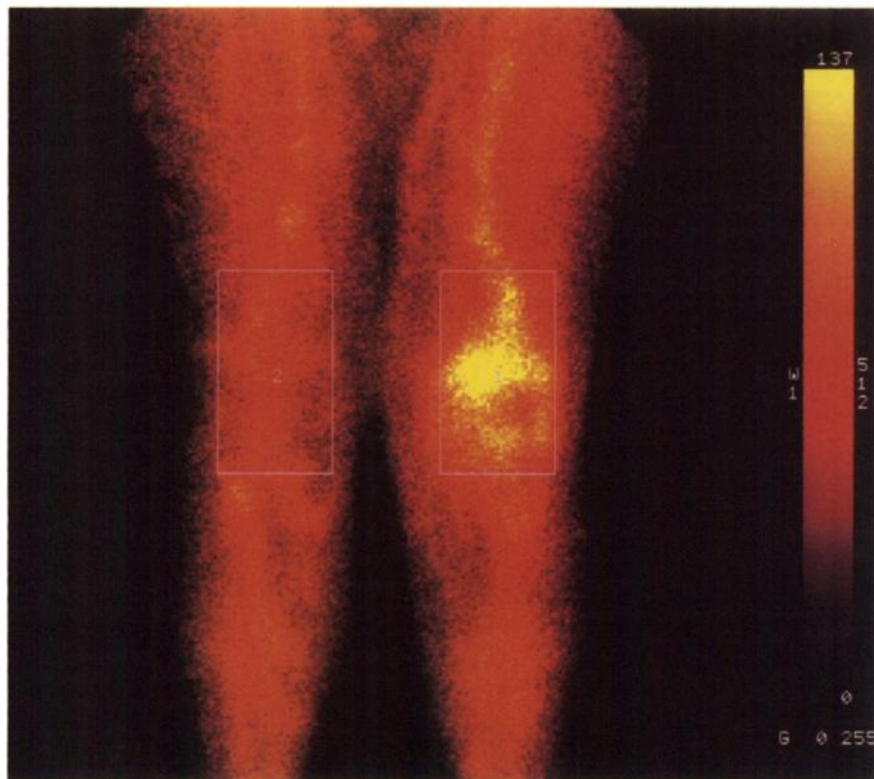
^{99m}Tc -HIG scintigraphy (4 h after intravenous injection) in patient with seronegative arthritis of left knee joint before radiation synovectomy. Active synovitis of left knee joint is visualized by markedly increased retention of tracer, whereas there is no evidence of any inflammatory process in right knee joint.
